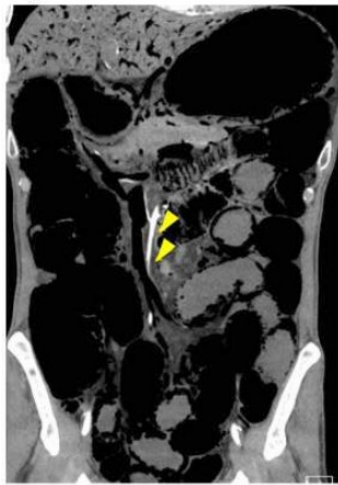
Coronal section of abdominal Computed Tomography (CT) showed a massive amount of hepatic portal venous gas and extensive intestinal ischemia, and blood flow of the superior mesenteric artery was maintained (arrows).
